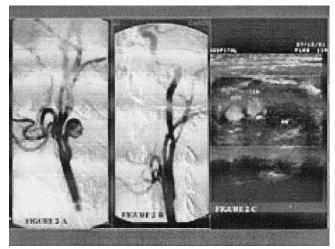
a, b & c. Patient with post-traumatic pseudoaneurysm involving left ICA. Digital Subtraction Angiogram film of left carotid bifurcation before (2-A) and after (2-B) stent deployment. Follow-up Carotid Doppler (2-C) shows thrombosis of pseudo-aneurysm (AN) with free flow in ICA and ECA.
